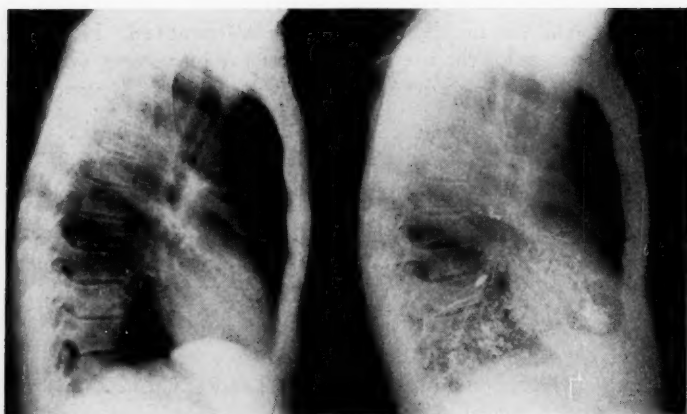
X-ray films in a case of carcinoma of right lower lobe in a male 50 years of age. Segmental atelectasis of posterior basal segment is seen in film at left and obstruction of segmental bronchus is clearly demonstrated by bronchogram at right. Point of obstruction was just beyond range of visibility in ordinary bronchoscopic examination but introduction of a small forceps into the posterior segmental bronchus rendered possible the securing of tissue which showed squamous cell carcinoma Grade II. Successful resection was carried out in this case and there has been no recurrence or metastasis in almost five years. (Case of Dr. Charles Norris, Chevalier Jackson Clinic, Temple University Hospital, reported in "Diseases of the Chest," Vol. XIV, No. 2, March-April, 1948.)
